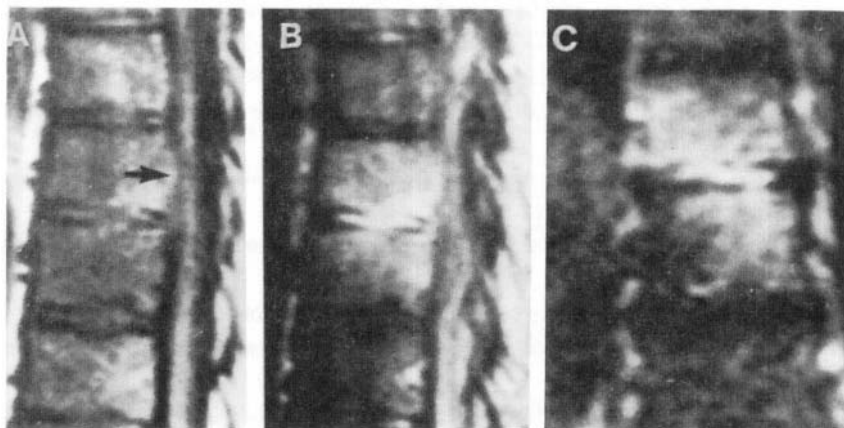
Brucellar spondylitis in lower thoracic spine of a 66-year-old Saudi man. Midsagittal T1-weighted image (a) of the spine shows minimal loss of signal in T9 and T10 vertebrae with a small area of intermediate signal intensity in the posterior part of T9 with epidural extension (arrow). T2-weighted image (b) shows diffuse high signal intensity in the vertebrae, epidural space, and the intervening disk. Coronal T2-weighted image (c) shows no evidence of paraspinal soft tissue abnormality. (Reprinted with permission from Sharif HS, Aideyan OA, Clark DC, et al. Brucellar and tubercular spondylitis: comparative-imaging features. *Radiology* 1989; 171 : 419–425.)
